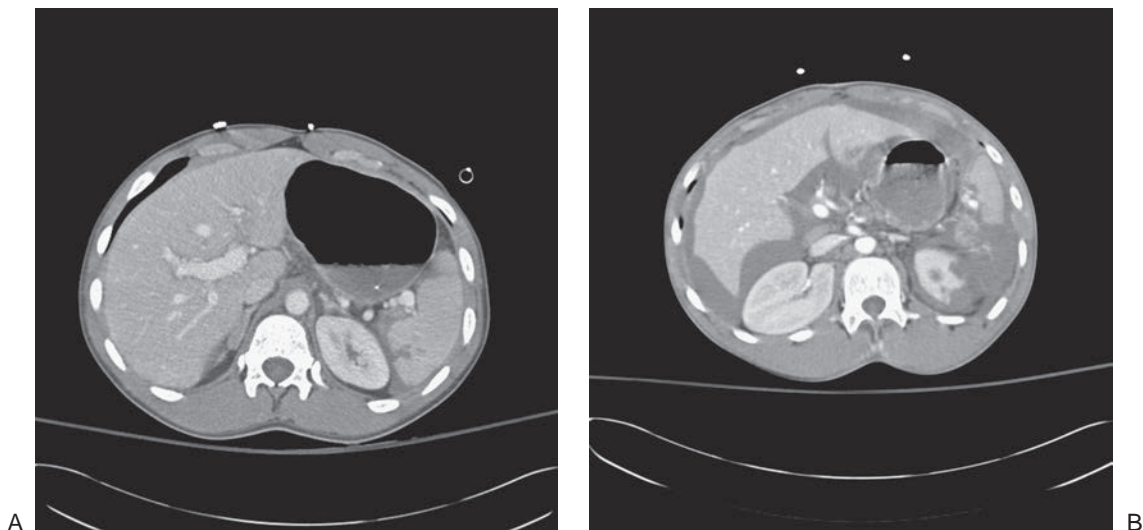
A: Contrast-enhanced CT showing a grade 1 splenic laceration in the inferior pole, with associated hemoperitoneum; the patient was successfully managed conservatively. B: Contrast-enhanced CT showing a grade 5 splenic laceration with evidence of active extravasation and perisplenic hematoma. This patient required urgent splenectomy.
